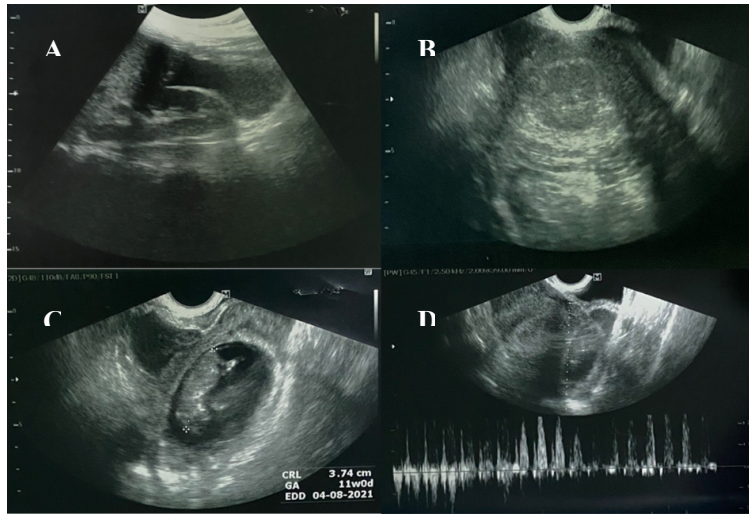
A: Transabdominal ultrasound exhibiting free fluid in the hepatorenal pouch
